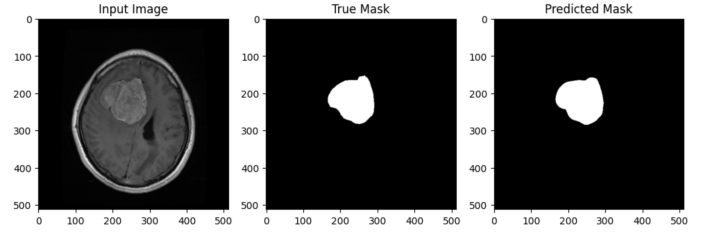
Sample Predictions: Input MRI, True Mask, and Predicted Mask, demonstrating the model's accuracy in identifying brain tumor regions.
